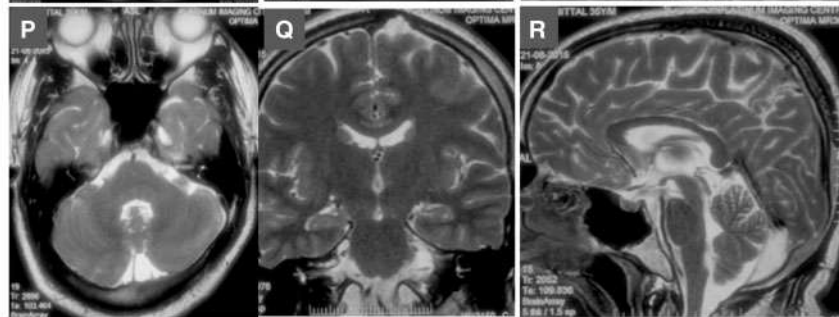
Representative brain MRI images of selected patients with different CAG length. MRI brain (A–C) of Patient AT872/2058 carrying CAG-14/43. Axial T₂-weighted images (A and B) showing cortical atrophy and white matter hyperintensities in bilateral middle cerebellar peduncle (arrows). (C) Sagittal T₂-weighted image showing prominent cerebellar atrophy. (D–F) MRI of Patient AT630/1683 carrying CAG-13/45. (D) Axial T₁-weighted image showing white matter hyperintensities in dorsal tegmentum (yellow arrow) and in superior cerebellar peduncle (white arrow) and mild degree of temporal lobe atrophy. (E) Fluid attenuation inversion recovery (FLAIR) axial image showing mild degree of parietal lobe atrophy. (F) Sagittal T₂-weighted image showing mild degree of cerebellar atrophy. (G–I) MRI of Patient AT476/1498 carrying homozygous CAG-45 repeats. (G and H) Axial T₂-weighted images showing moderate degree of parietal lobe atrophy, multiple punctuate lesion and (I) sagittal T₂-weighted image showing mild degree of cerebellar atrophy. (J–L) Brain MRI of Patient AT3500/4301 carrying CAG-10/47. Axial T₂-weighted (J), coronal T₂-weighted (K) and sagittal T₂-weighted (L) images showing mild generalized cortical atrophy and no cerebellar atrophy. (M–O) MRI brain of Patient AT1403/2800 carrying CAG-10/49. Axial T₂-weighted (M) and axial FLAIR (N) images showing moderate degree of cortical atrophy and diffuse multiple punctuate lesions and sagittal T₂-weighted (O) image showing mild degree of cerebellar atrophy. (P–R) MRI brain of patient carrier of heterozygous typical pathogenic length CAG-51. Axial T₂-weighted (P), coronal T₂-weighted (Q) and sagittal T₂-weighted (R) images showing normal-appearing brain parenchyma. (S–U) MRI brain of patient carrier of biallelic repeat expansion (Patient AT648/2017) CAG-42/51. Axial T₂-weighted (S), coronal T₂-weighted (T) and sagittal T₂-weighted (U) images showing normal-appearing brain parenchyma.
